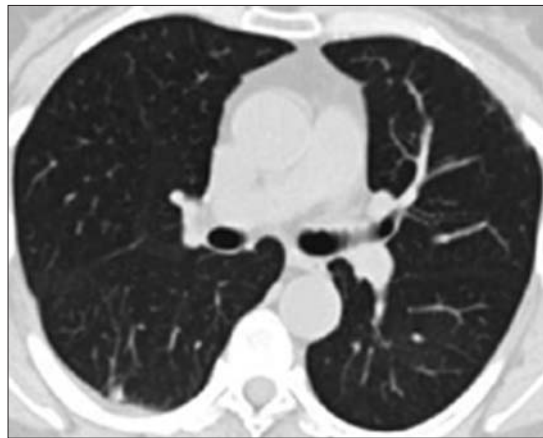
Follow-up CT examination after increasing the steroid dose shows normalizing of both lungs.
